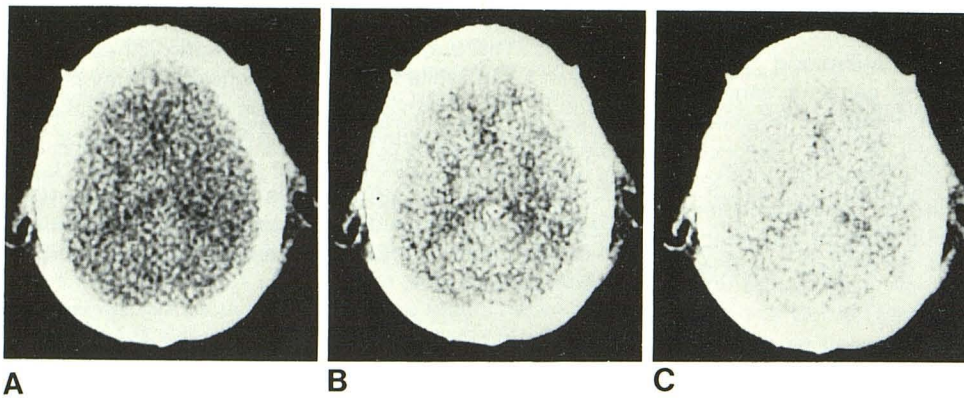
Serial xenon CT, frontal horn level. Baseline image (A) compared with scans 2 (B) and 5 (C) min after initiation of xenon (80%) inhalation. Delayed enhancement of internal capsule region as compared with predominantly gray matter structures.
